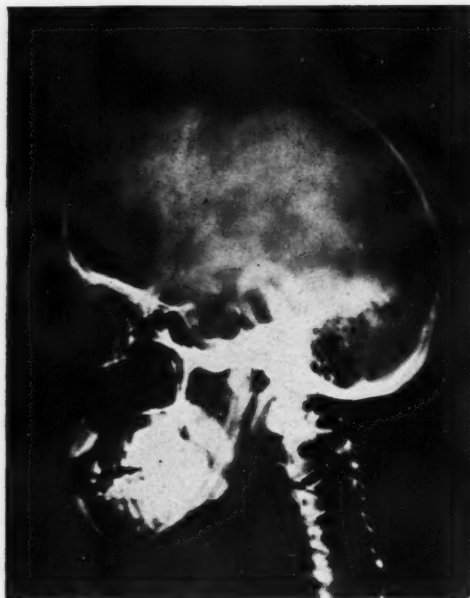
X-ray No. 19,752. Man, age 30. *Complaint:* Failing vision. *P. E. shows* primary optic atrophy. *Operation:* Right transfrontal with partial removal of a cystic pituitary adenoma. *Pathological report:* Pituitary adenoma. *X-ray shows* an expanded pituitary fossa without signs of increased pressure, compatible with a pituitary adenoma.
